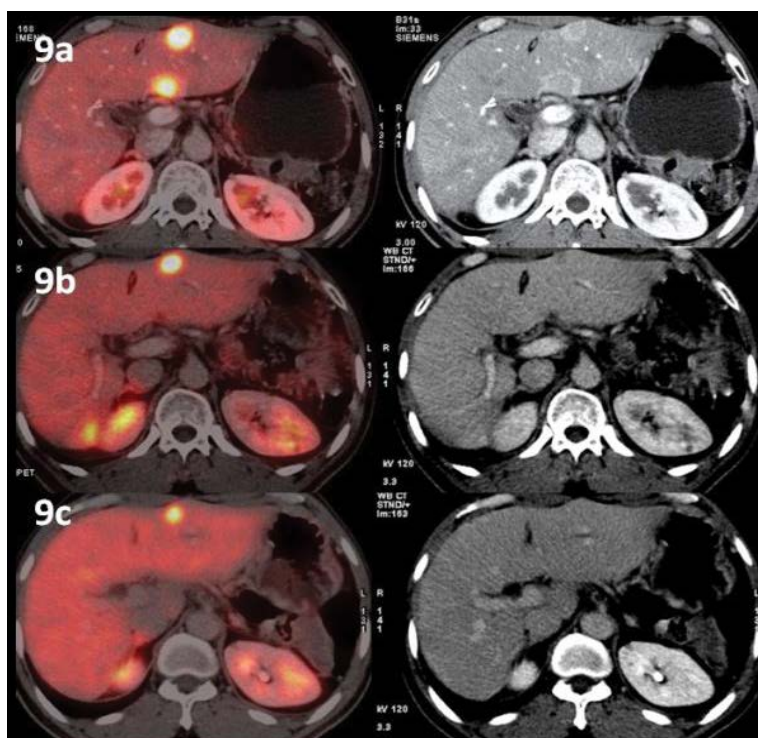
Patient 2- Baseline ^{68}Ga -DOTANOC PET CT showed multiple SSR avid hepatic metastasis in both lobes predominantly in the left lobe, with a focal SSR avid extrahepatic soft tissue deposit in the left rectovesical pouch. b) Post 2 cycles of IA infusion of PRRT, there was significant reduction in size and intensity of tracer uptake in the liver lesions with further decrease in size and metabolic activity after 4 cycles (Figure 10b) suggestive of partial response.
